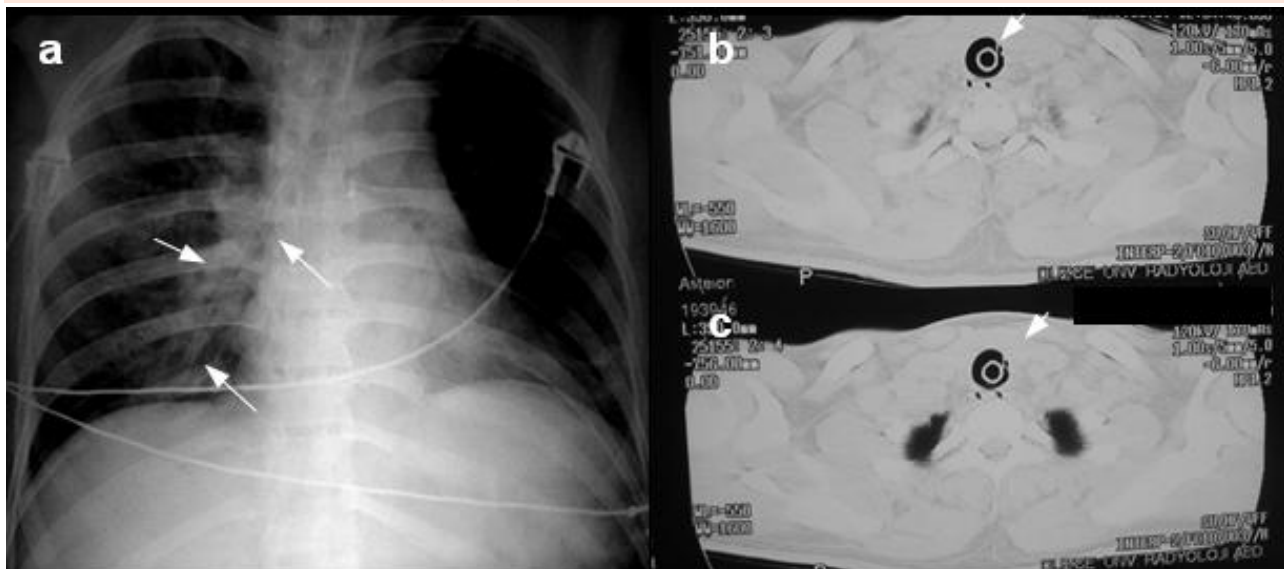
(a) Chest x-ray presenting endotracheal tube and a thinner tube (nasogastric tube) in the trachea and right main bronchus (b and c) Thoracic CT presenting endotracheal tube and a nasogastric tube in the trachea.
